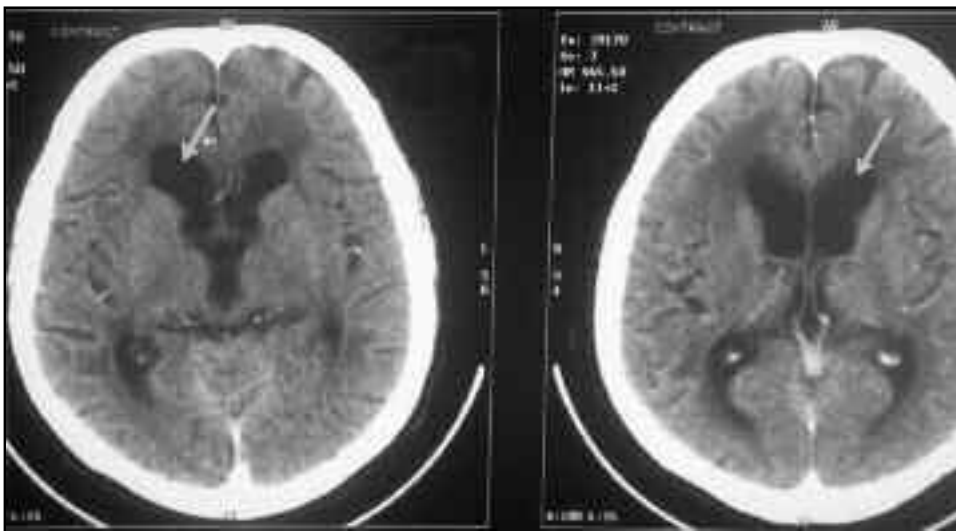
Contrast CT of the patient showing dilated lateral ventricles.
